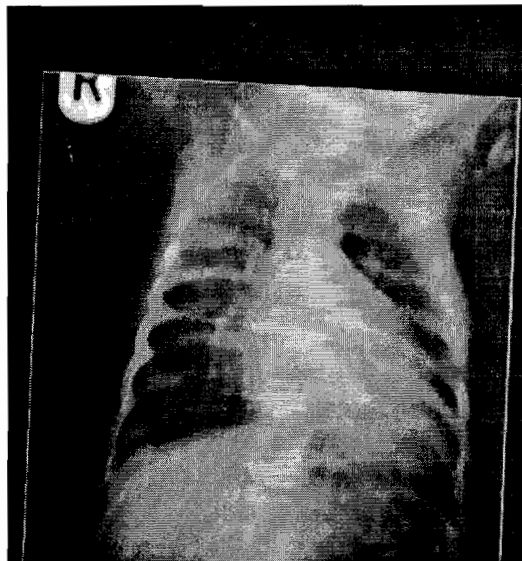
Chest X-Ray showing the classical "egg-on-side" appearance in TGA
